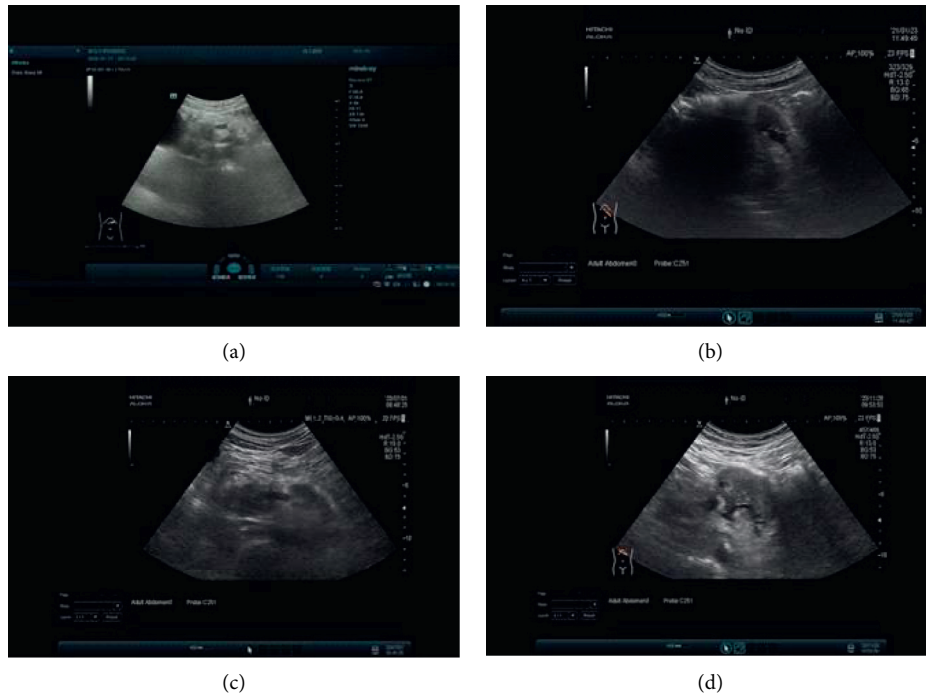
Color ultrasound image of a pancreatic cancer patient. (a) PC stage I: ultrasound showed hypoechoic nodules in the head of the pancreas with irregular shape and ill-defined boundaries,  $1.9 \times 1.7$  cm. (b) PC stage II: ultrasound showed a hypoechoic nodule in the head of the pancreas with irregular shape and ill-defined boundaries,  $2.6 \times 1.7$  cm. (c) PC stage III: ultrasound showed a low-echoing mass in the head and body of the pancreas, with irregular shape, poorly defined boundary, and poorly defined with surrounding tissues,  $5.5 \times 3.5$  cm. (d) PC stage IV: ultrasound showed a hypoechoic mass in the tail of the pancreatic body, with irregular shape, ill-defined boundary, and unclear boundary with surrounding tissue,  $6.9 \times 4.2$  cm, surrounded by adjacent arteries.
